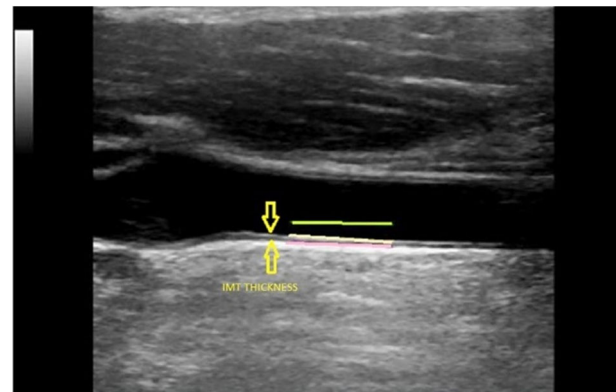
Assessment of carotid IMT. Measurement of the IMT of the CCA by high-resolution B-mode ultrasonography. IMT was measured by an automatic function algorithm as represented by the yellow and pink lines (the green line in the lumen of the CCA represents the reference value for the arterial wall echo gradient calculations). The yellow arrows fence the IMT thickness. CCA: Common carotid artery; IMT: Intima–media thickness.
